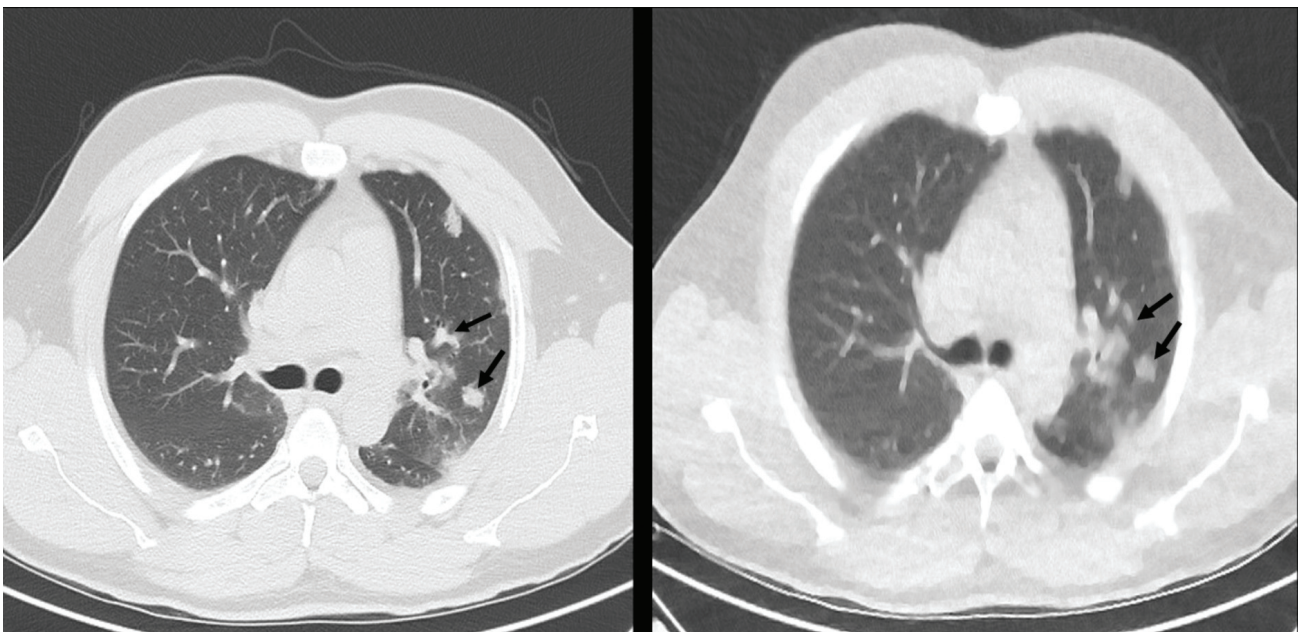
This figure shows the appearance of multiple lung nodules in (a) standard dose and (b) ultra-low dose chest CT (black arrows) images.
